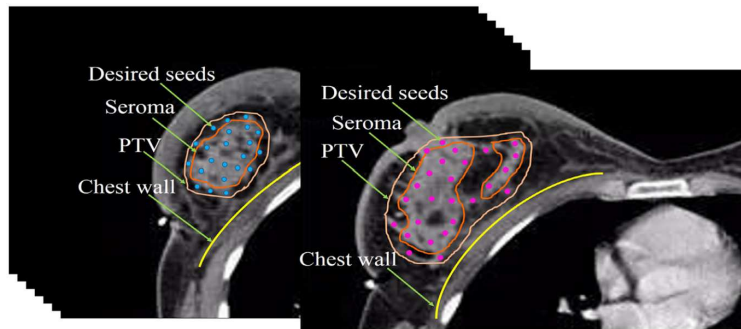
Seed-implantation task in the CT volume [63].
